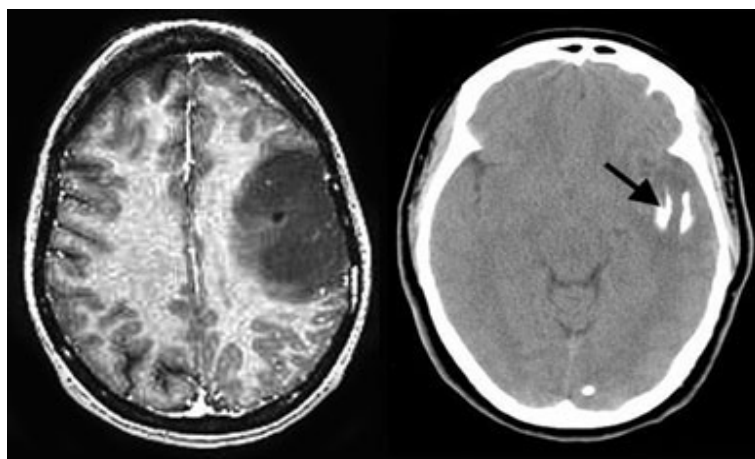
The MRI image (left) of a large oligodendroglioma in a left frontal lobe. Corresponding CT scan (right) indicates partial calcification of the tumor (arrow). Image courtesy of Department of Radiation Oncology UCLA (UCLA, 2013).
